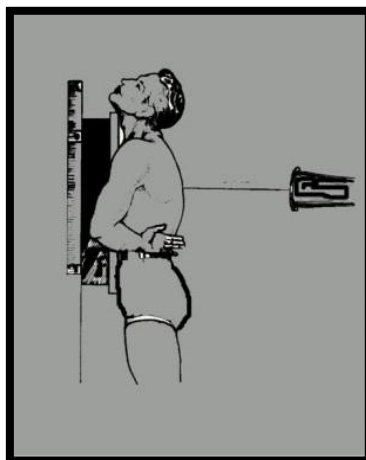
Chest X-ray PA projection
